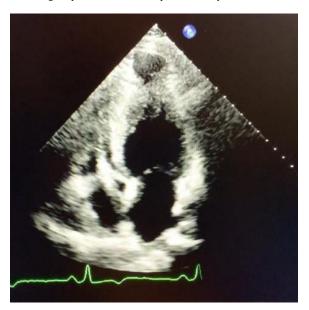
2 D echocardiogram. Apical 4 view chamber showing hypertrophied mid LV with mid-cavity narrowing
